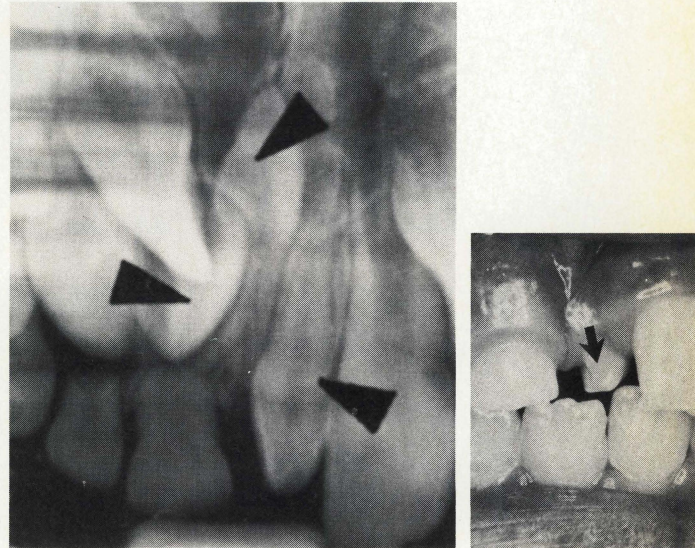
A and B. The patient as seen on initial examination. One supernumerary is partially erupted but all three are evident on the radiograph (arrows).
